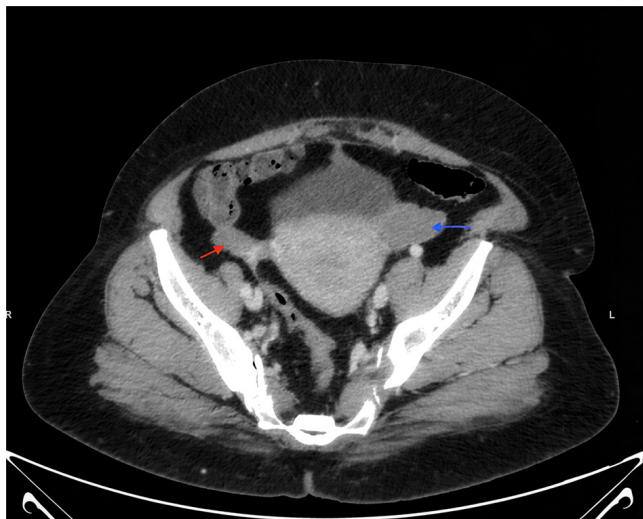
Axial contrast-enhanced computed tomography scan (delayed phase) demonstrating bilateral enhancing ovarian tumors (right ovarian tumor, red arrow; left ovarian tumor, blue arrow).
